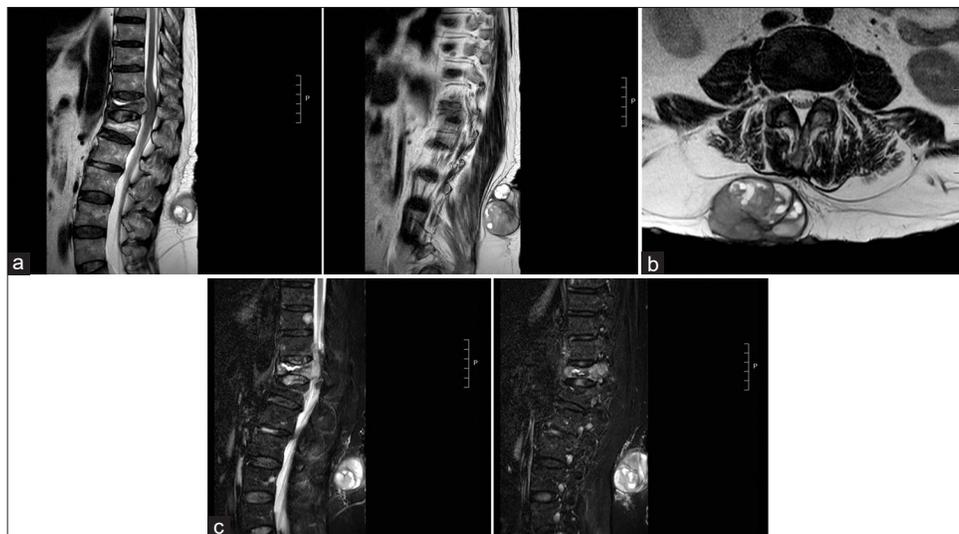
Preoperative thoracolumbosacral MRI T2-weighted sagittal (a) and axial (b) images documented a T12 burst pathological fracture with severe spinal cord compression by a thick epidural tissue and a large subcutaneous paraspinal ovalar lesion ($54 \times 60 \times 39$ mm). These lesions appear inhomogeneously hyperintense on STIR sequences (c).
